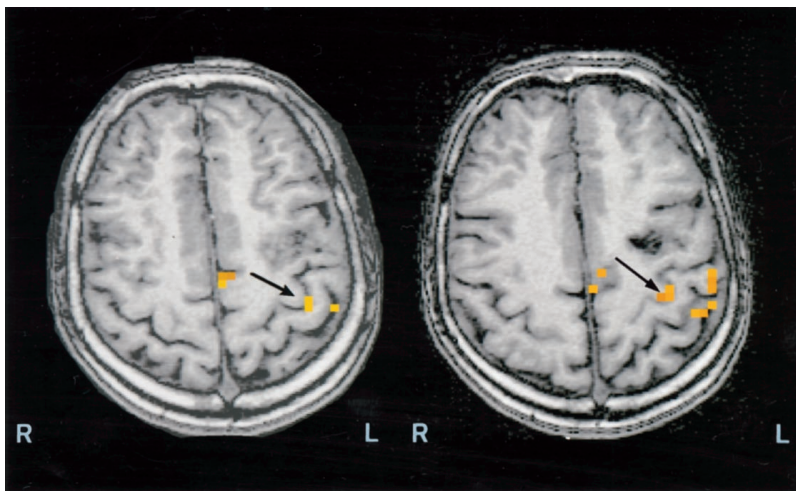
Anatomical MRI showing left precentral arteriovenous malformation (AVM) with superimposed functional MRI (carried out by means of 1.5-T MRI using the blood-oxygen level-dependent method during right-hand movement). Motor activations were obtained in and behind the anatomically presumed central sulcus (arrow) but not close to the AVM as expected. We also noted activations in the left supplementary motor area. L = left; R = right.
